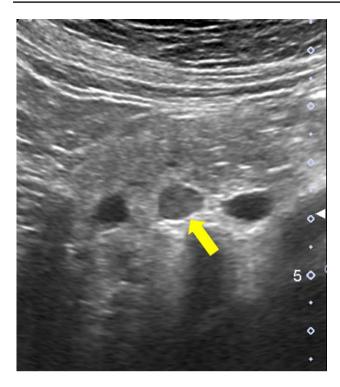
Abdominal ultrasound revealed a 9-mm, clearly demarcated, hypo-echoic mass within the pancreatic body (arrow)
